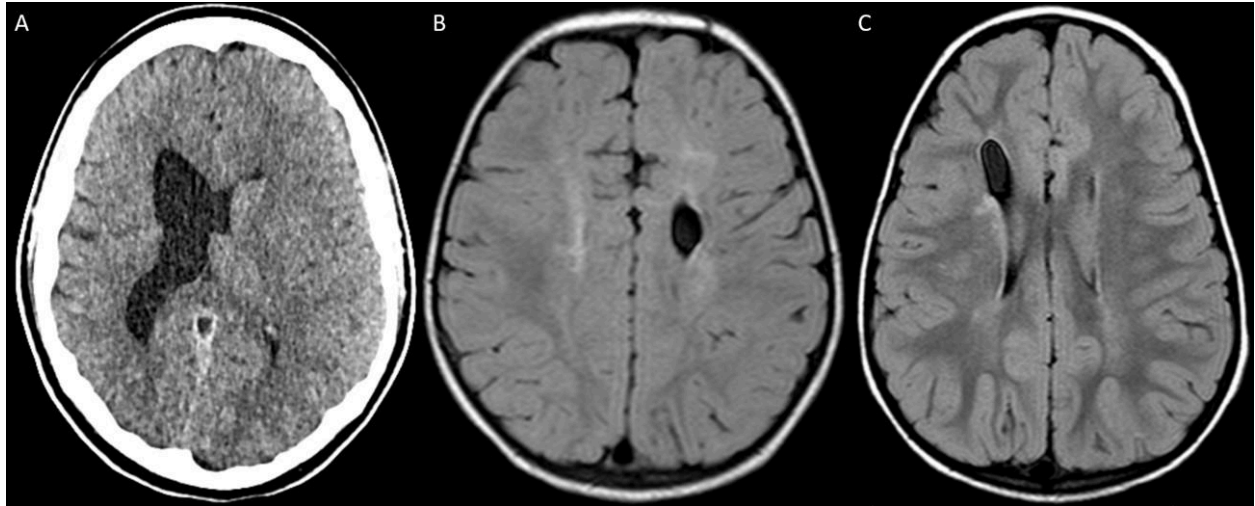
Select images from family 1 with G1103R variant. (A) CT head shows unilateral ex vacuo ventriculomegaly and mild cerebral volume loss (secondary to patient's intrauterine stroke), case 6 at 15 years old. (B) Axial T2 FLAIR shows unilateral porencephaly, bilateral white matter hyperintensity, case 7 at 2 years old. (C) Axial T2 FLAIR shows unilateral porencephaly, bilateral white matter hyperintensity, case 8 at 3 years old.
